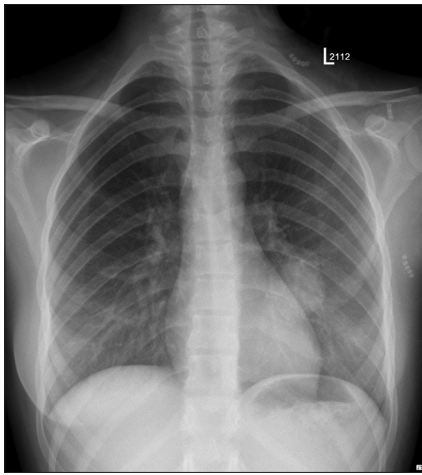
Chest X-ray showing a well-defined, rounded left lung opacity, measuring around 4 cm x 4 cm and devoid of calcification or air-fluid level
